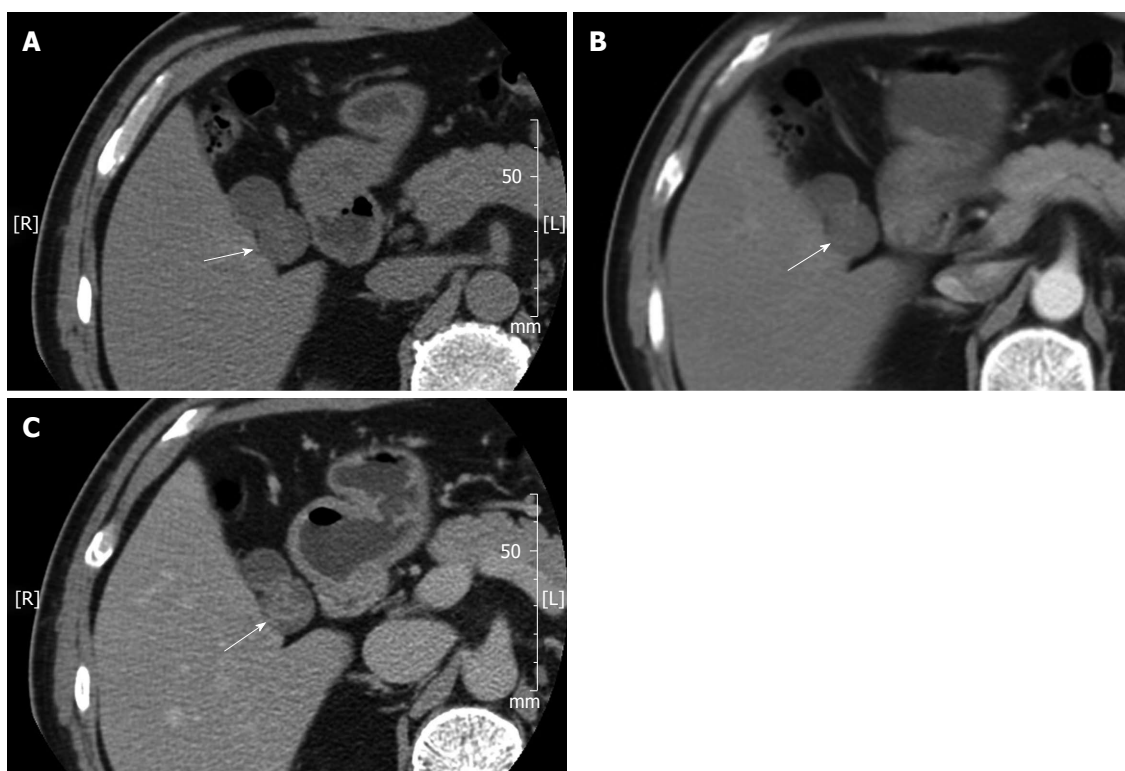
Gallbladder computed tomography imaging. A: Unenhanced computed tomography shows an iso-attenuating mass (arrow) in the gallbladder; B: No obvious enhancement (arrow) was found in the arterial dominant phase; C: The mass (arrow) shows slight hyper-attenuating in the late venous phase.
